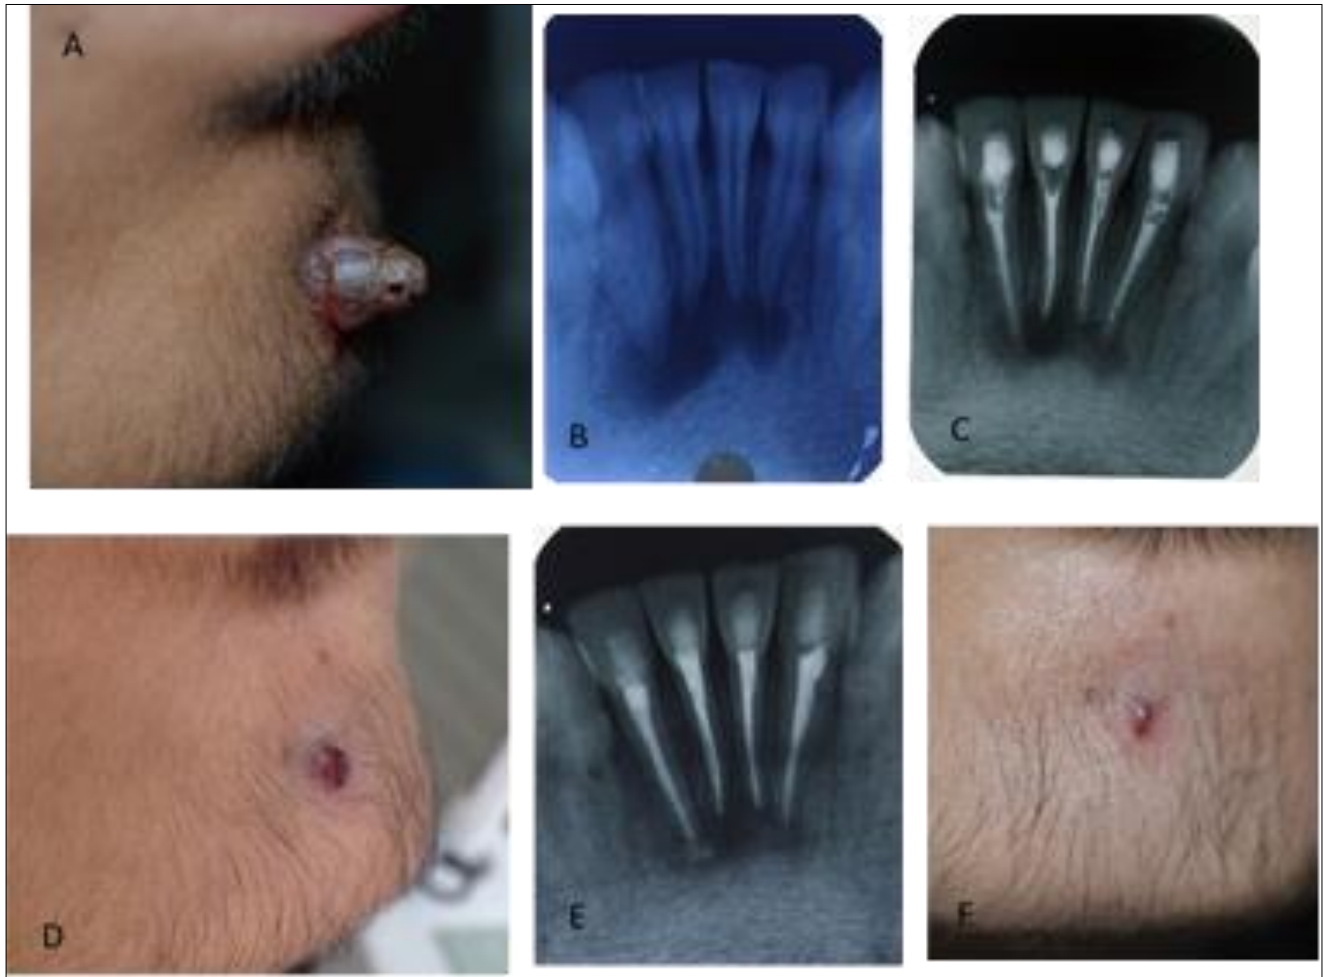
Odontogenic cutaneous fistula of the Chin region. (A) Extraoral photo; showing abscess on chin. (B) Diagnostic preoperative IOPA radiograph of mandibular incisors showing periapical radiolucency associated with a cutaneous odontogenic fistula. (C) Endodontic treatment of mandibular centrals with Calcium hydroxide as intracanal medicament (D) Healing after 1 week of endodontic therapy (E, F) 1 year followup
